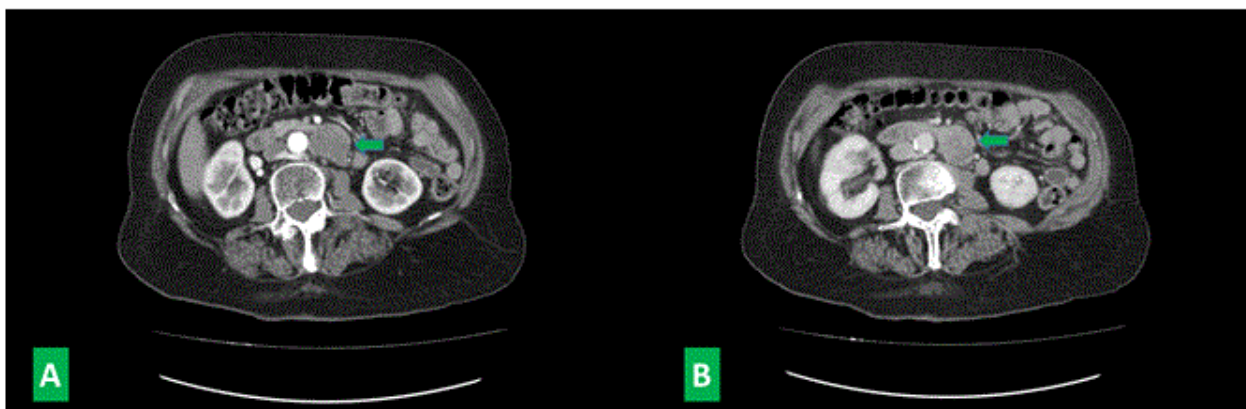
Contrast enhanced abdominal CT scan showed retroperitoneal roundish mass (Green arrows) with well-defined edge and no early (A) or late (B) contrast enhancement.
